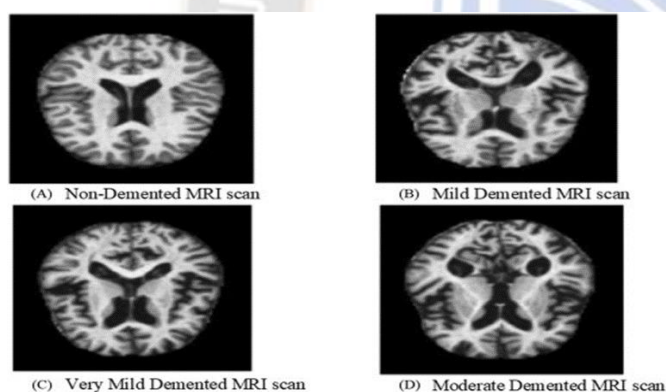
MRI Scans of Different Stages of Alzheimer's Diseases
